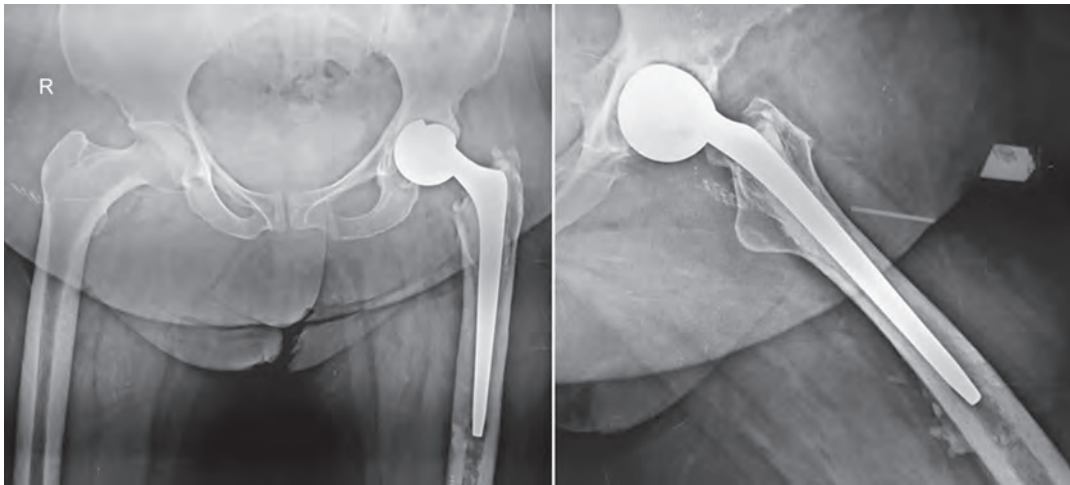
Preoperative X-ray: The acetabular component separated from the femoral component
